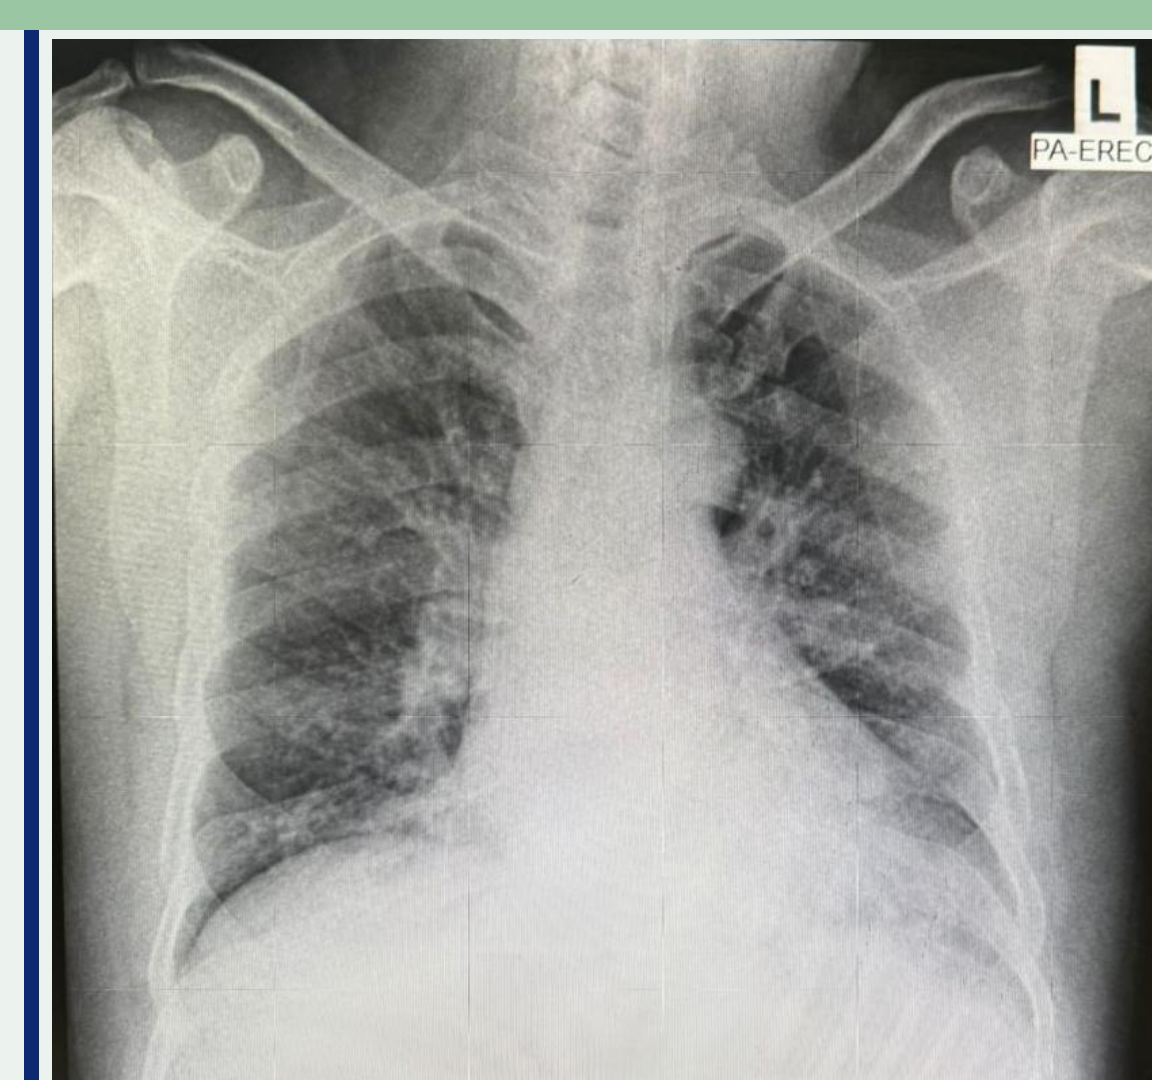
Chest X-ray showed Left lower lobe opacity with obscured left cardiac border
